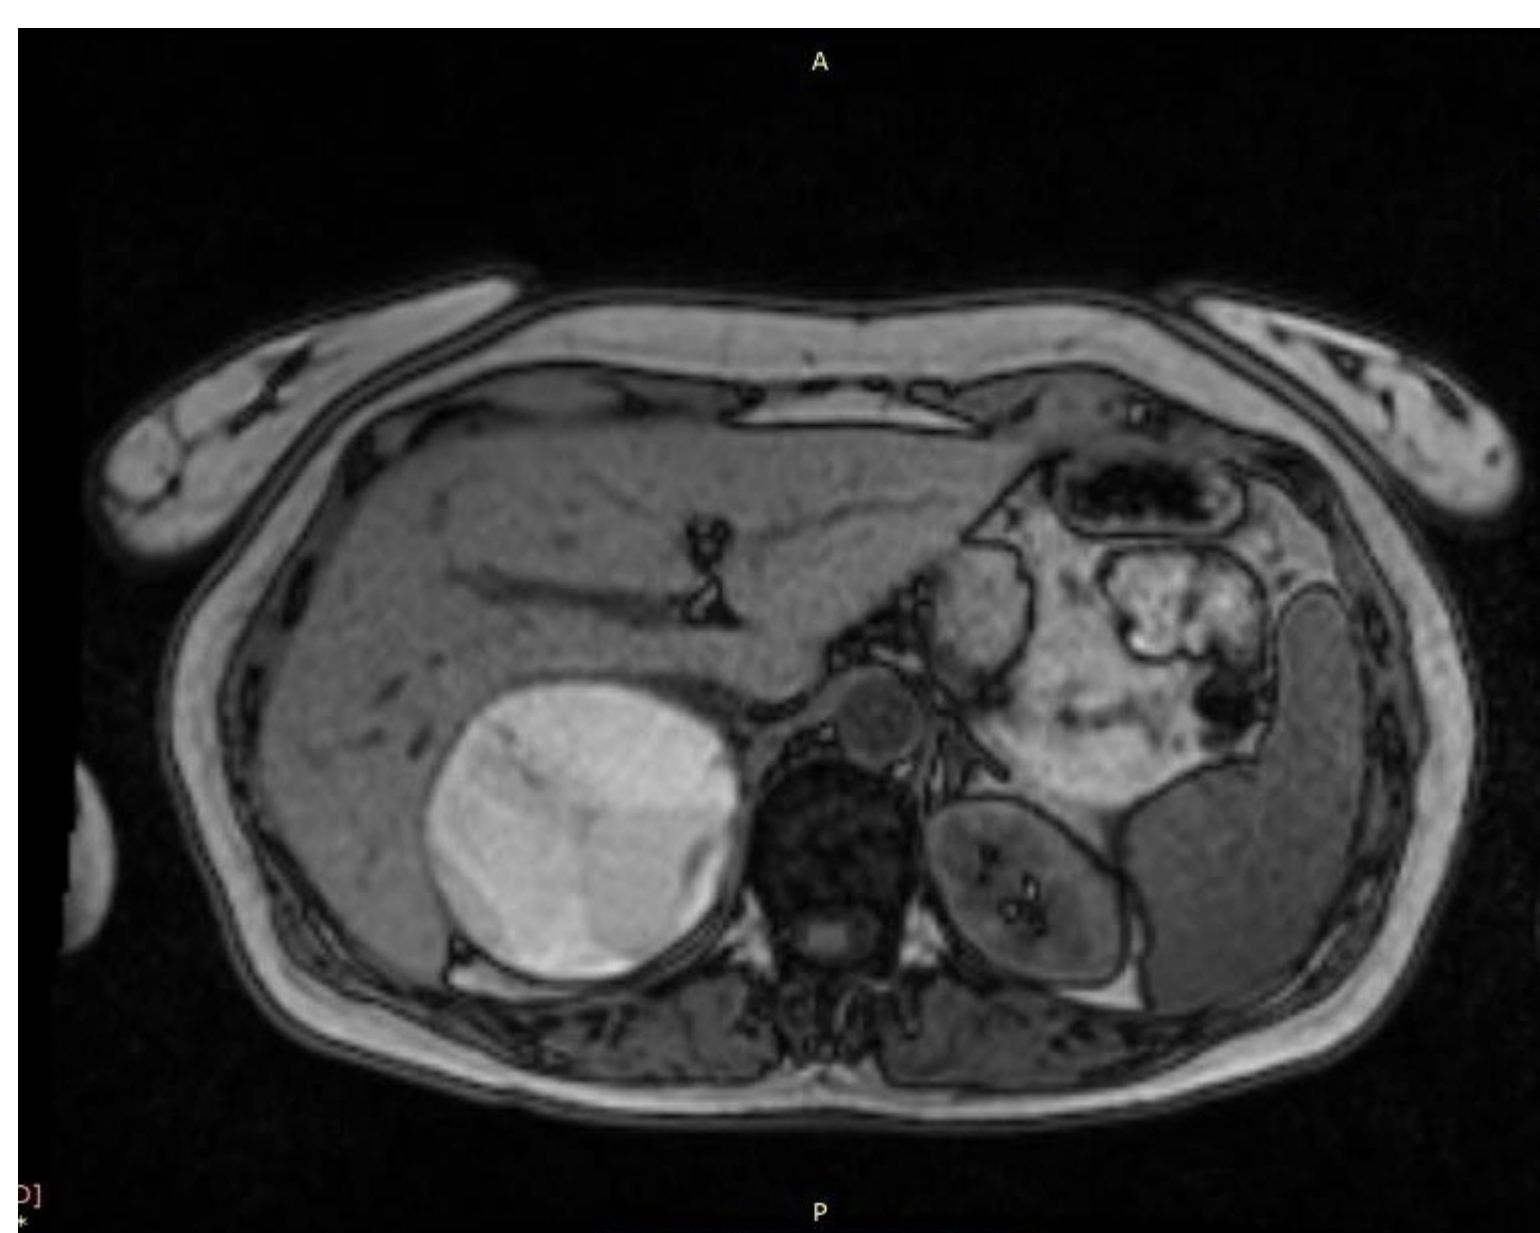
MRI image shows adrenal cystic lesion with high signal intensity on T2-weighted images, fluid-fluid levels and septation of the lesion.
